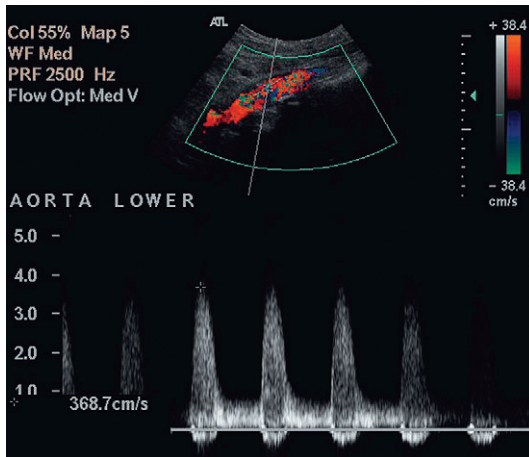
Colour Doppler image of a stenosis in the middle aortic segment showing significant turbulence and a peak systolic velocity of 3.7 m s^{-1} .
